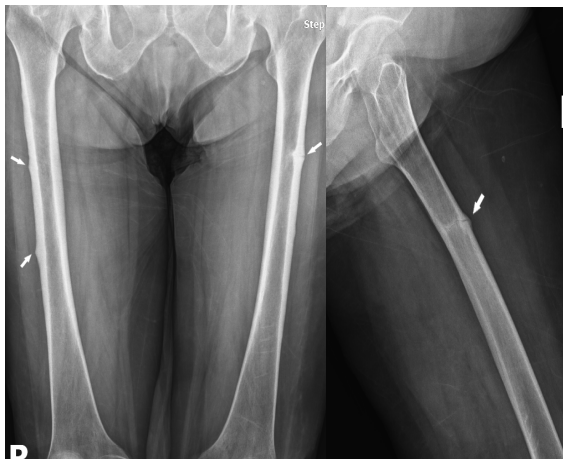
Radiographs showed 3 focal thickenings (A) of the lateral diaphyseal cortex, 1 of them with a visible crack (radiolucent line >1/2 of bone diameter) on the left femur (B).
